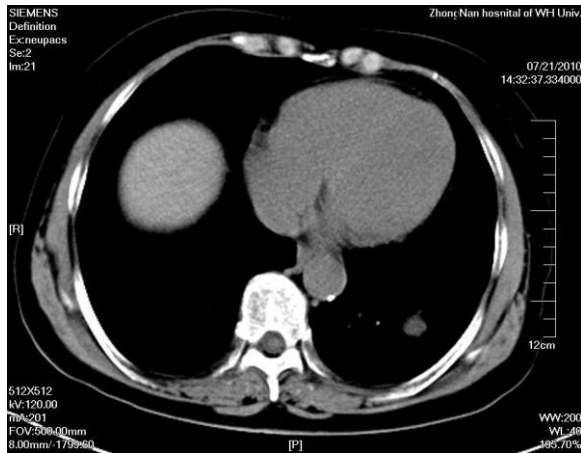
Non- contrast enhanced CT scan demonstrates a homogeneous nodule in the left lower lobe.
